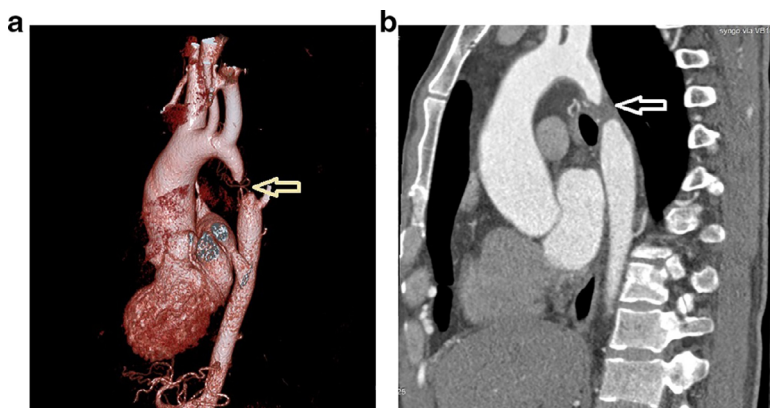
Interrupted aortic arch in aortic computed tomography angiography. (a) 3D reconstruction and (b) interruption site (arrow) and collateral vessels (*).
